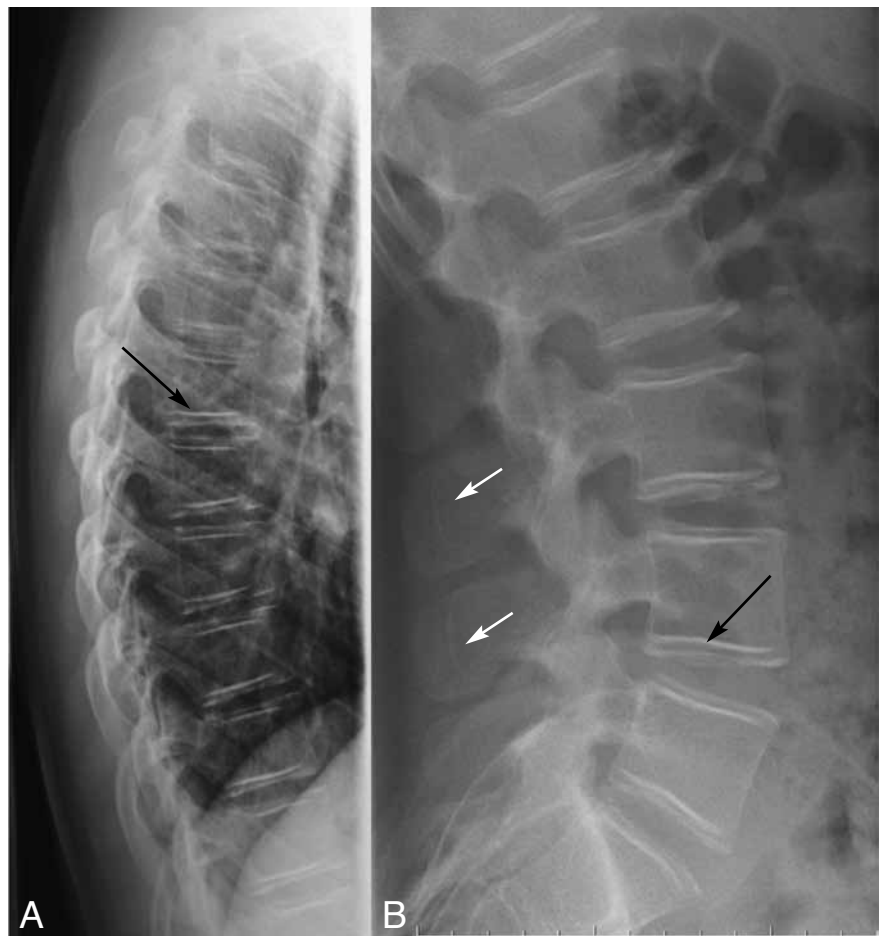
Lateral plain films of the thoracic (A) and lumbar (B) spine. Vertebral bodies are all delineated by a double bony cortex creating an impressive "bone-within-bone" or "vertebra-within-vertebra" configuration (black arrows). Duplication of the bony cortex is also visible at the level the vertebral spinous processes (white arrows).
